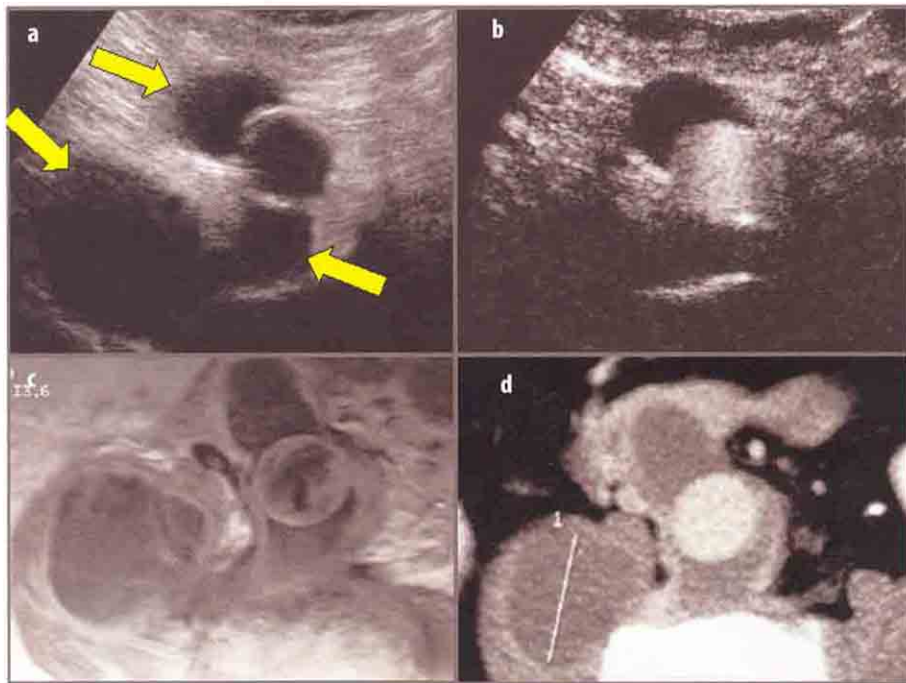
Surgical aortic stentgraft with peripheral fluid collections. a Transversal scan, B-mode. A linear hyperechoic rounded structure corresponding to the aortic graft is evident; anteriorly, posteriorly and in right postero-lateral position three anechoic images (yellow arrows) are detectable peripheral to the prosthesis, but strictly adherent to the prosthetic wall (possibly peri-prosthetic collections or anastomotic pseudo-aneurysm). b Transversal scan, CEUS. The prosthetic lumen is regularly enhanced by contrast agent; none of the three collections is filled with contrast, and therefore they are excluded by vascular bed. Peri-prosthetic collections. c-d Angio-RMN and angio-CT corresponding planes. No vascular supply is detected inside the three collections
